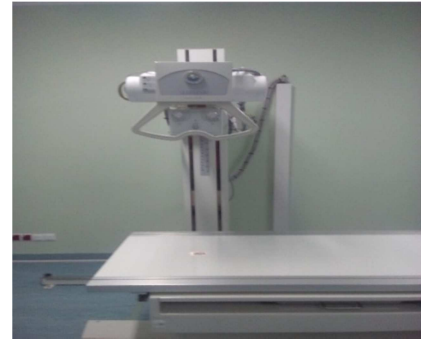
Radiographic device configuration for the X-ray radiation output measurement.
